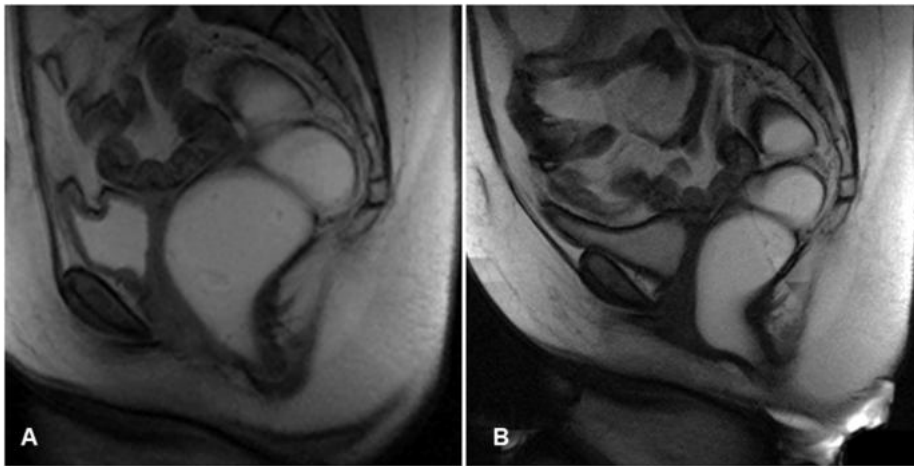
Spastic pelvic floor syndrome. Rest (A) and Evacuation (B) Sagittal MRI T2WI shows unsatisfactory decency of the pelvic floor during evacuation, with failure to open the anal canal and increase the anorectal angle.
